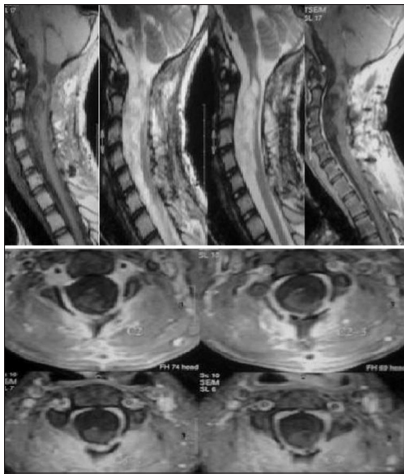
Immediate post-operative contrast MRI showing adequate excision and no residual contrast enhancing regions
